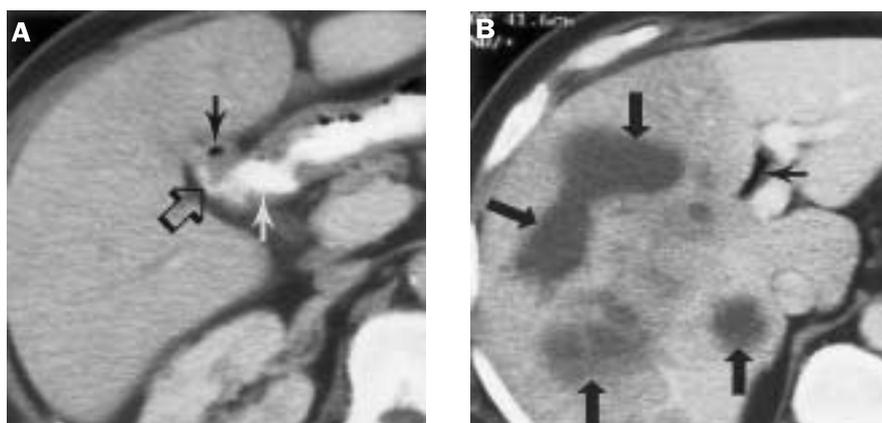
Contrast-enhanced CT scan of the abdomen
